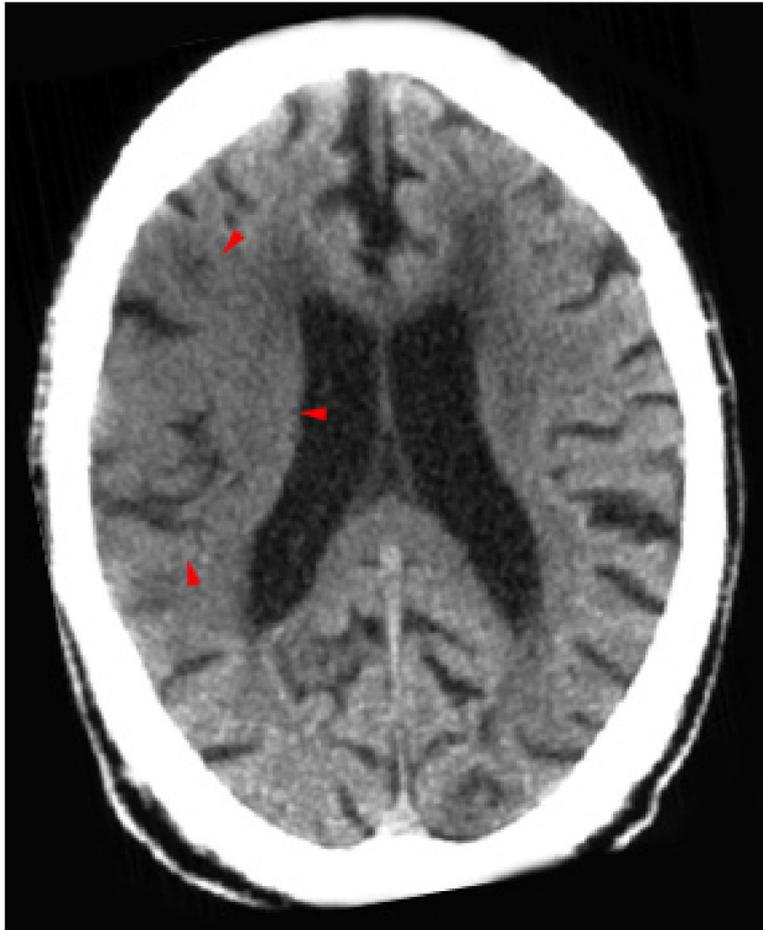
CT Head scan showing a right sided ischaemic stroke (red arrow).
